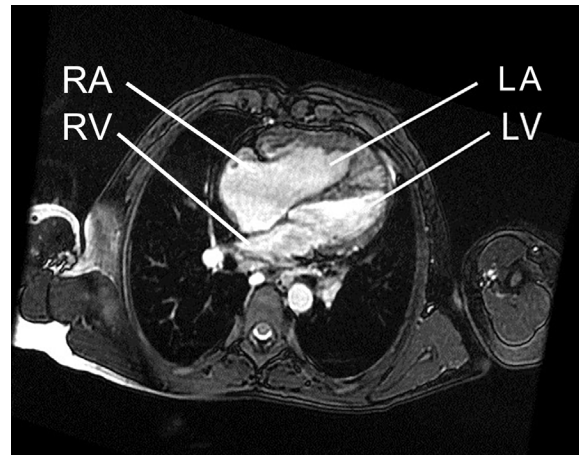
MRI – 10-year-old patient with Tetralogy of Fallot with pulmonary atresia s/p Glenn shunt showing a small left ventricle and a dilated right ventricle. (LA – left atrium, LV – left ventricle, RA – right atrium, RV – right ventricle).
